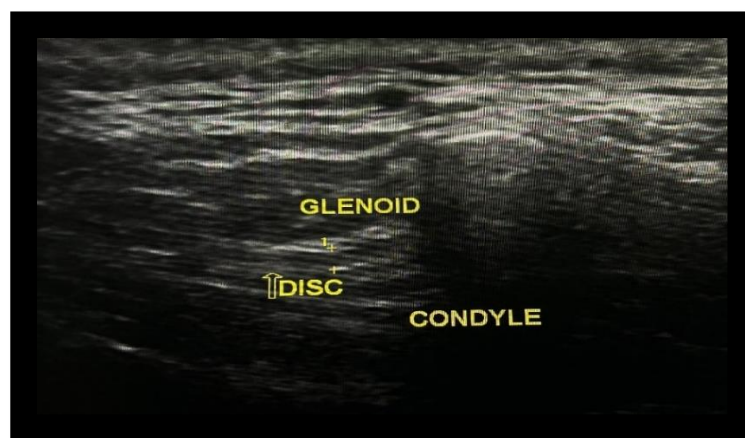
Ultrasonography showing normal disc position with joint space measurement
